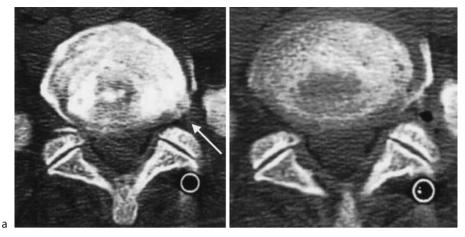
a Preoperative computed tomogram after discography at the L5-S1 disc level showing left extraforaminal lumbar disc herniation (*arrow*). b Postoperative plain computed tomogram at the L5-S1 disc level
